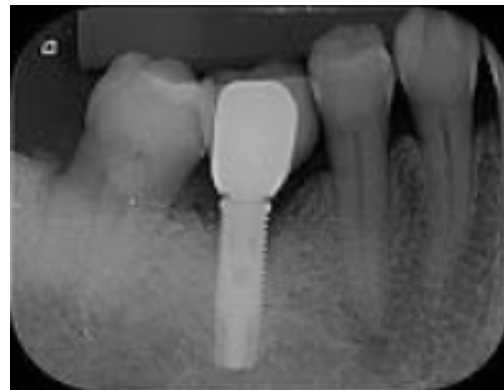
Periapical radiographic image 6 months after the treatment, with reduction of the peri-implantitis bone defect
